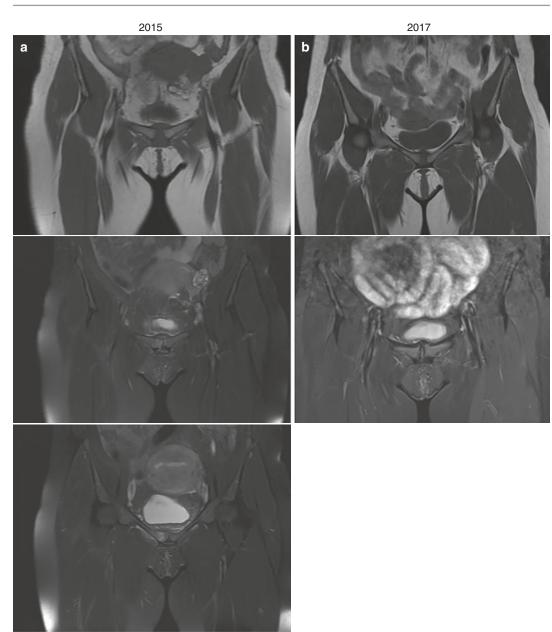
RM images of spontaneous resolution of pubic diastasis. (a) Pelvic diastasis developed during childbirth in 21-year-old women. The MRI shows bone edema and widening of the pubic symphysis. (b) Two
